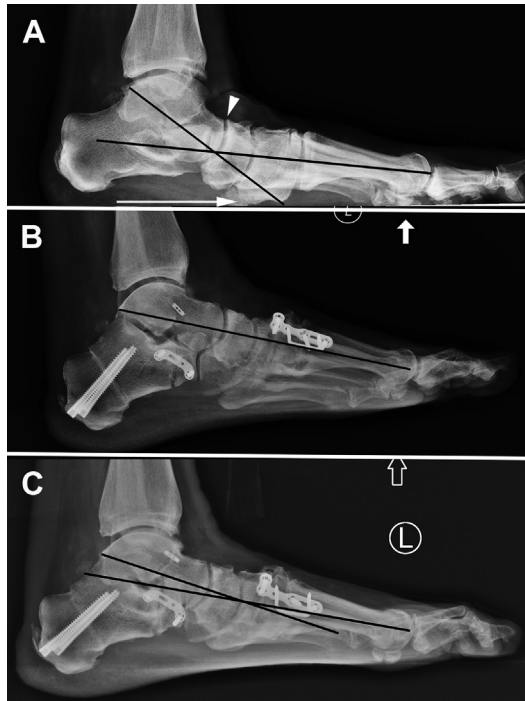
Lateral preoperative radiograph (A) of the same patient in [Fig. 3](#), with complete collapse of the medial column with contact of the cuneiform with the floor (*white arrow*). Note the lack of dorsal subluxation of the navicular relative to the talus (*white arrowhead*). This finding should alert the surgeon to the presence of medial column instability. Excellent sagittal plane correction (B) was achieved 3 months postoperatively. However, moderate loss of correction was noted at (C) 1 year secondary to persistent instability of the NC joint with associated loss of coronal plane correction (see [Fig. 3](#)).
